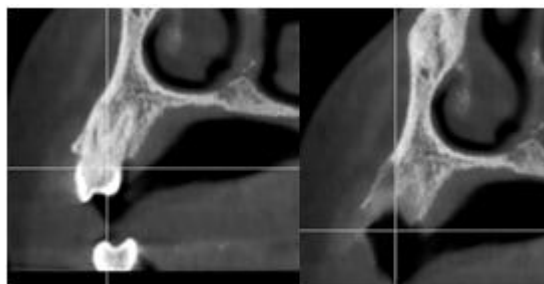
CBCT evaluation of the bone level
